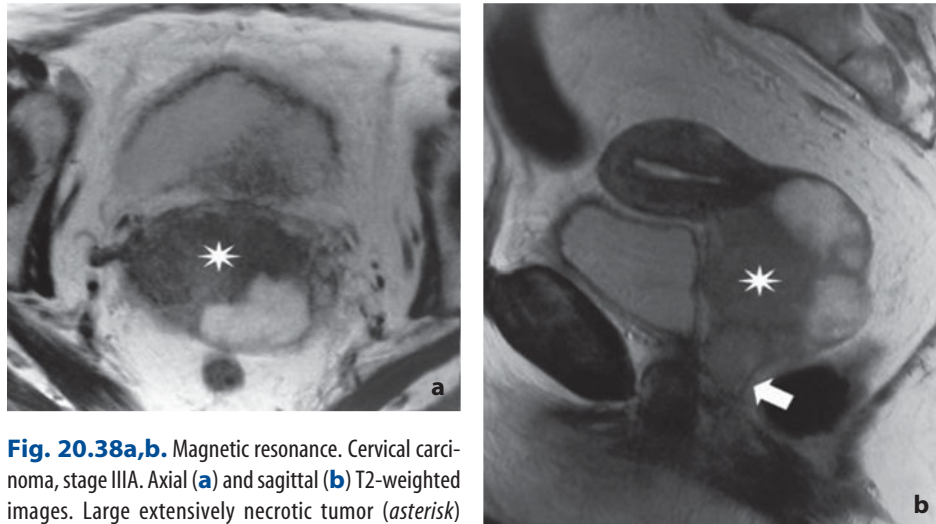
Magnetic resonance. Cervical carcinoma, stage IIIA. Axial (a) and sagittal (b) T2-weighted images. Large extensively necrotic tumor (*asterisk*) invading the vagina up to the inferior third (*arrow*)
